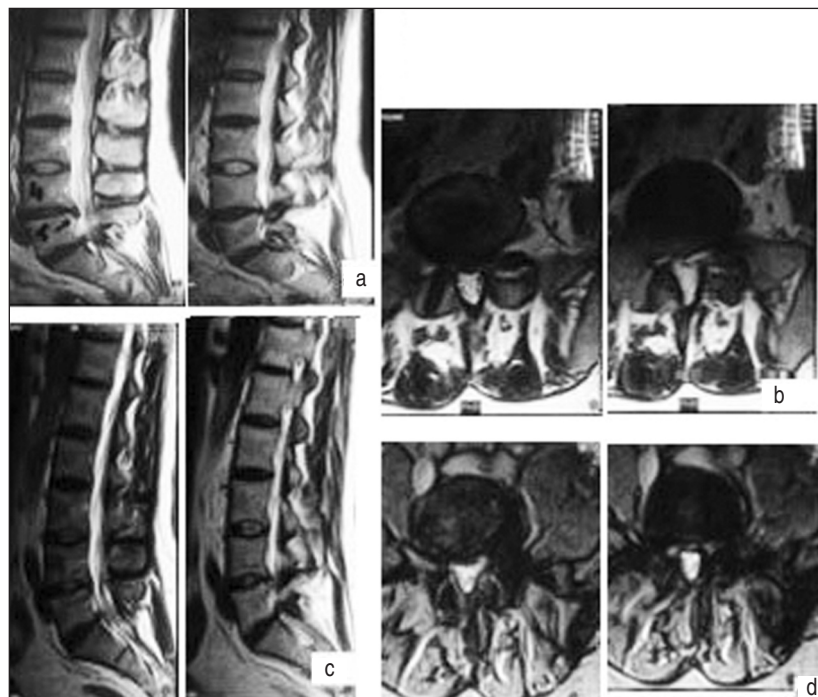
Sagittal (a) and axial (b) MRI demonstrating a right paramedian extruded disc at L5-S1 level and compressing the right S1 root; as compared to the sagittal (c) and axial (d) MRI scans of the same patient one year later.
